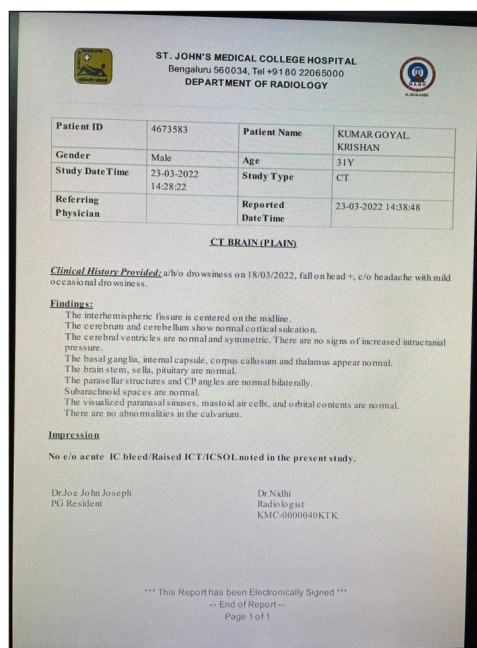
CT Scan 23/03/2022
